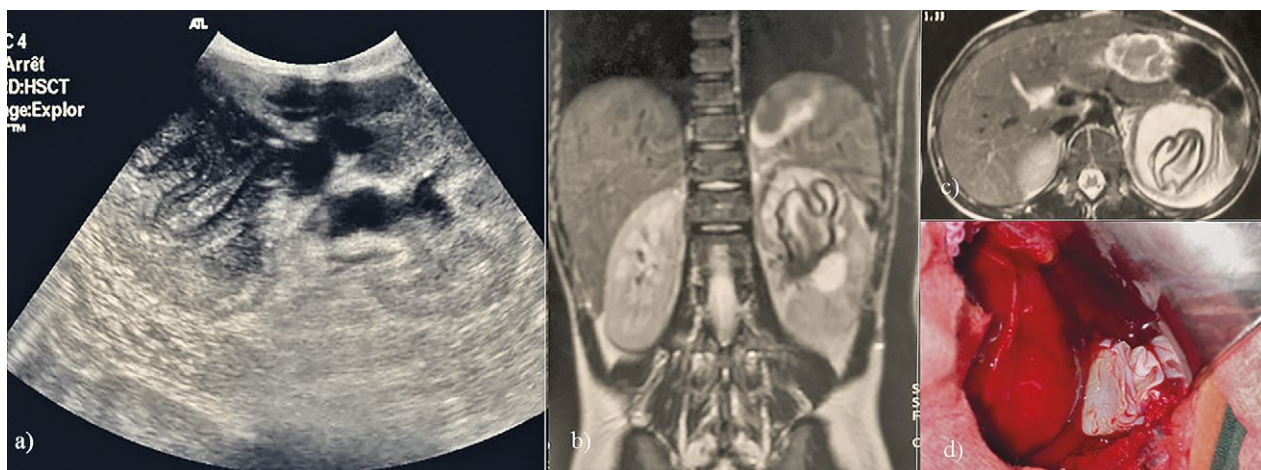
Left renal hydatid cyst with floating membranes following rupture of the cyst into urinary tract. A 10-year-old boy presented with left lumbar pain and intermittent passage of grape-like structures in the urine for the last three months. Sagittal ultrasound scan shows a complex cystic lesion of the left kidney with hydronephrosis (a). MRI coronal (b) and axial (c) T2-weighted images show the detached germinative membrane, intra-operative view of total external capsule excision (d).
